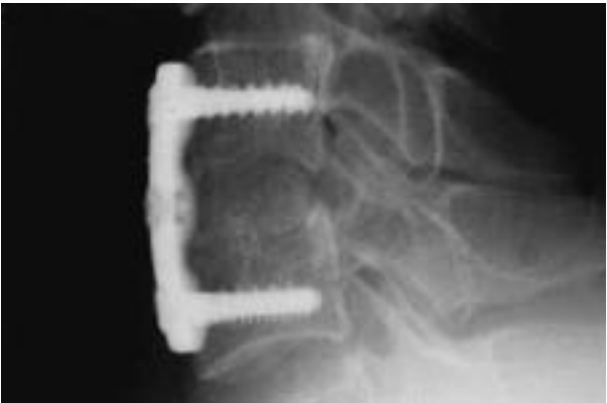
This simple cervical lateral radiograph shows the fact that the "Initiation of bone union" is "Cancellous Portion".
